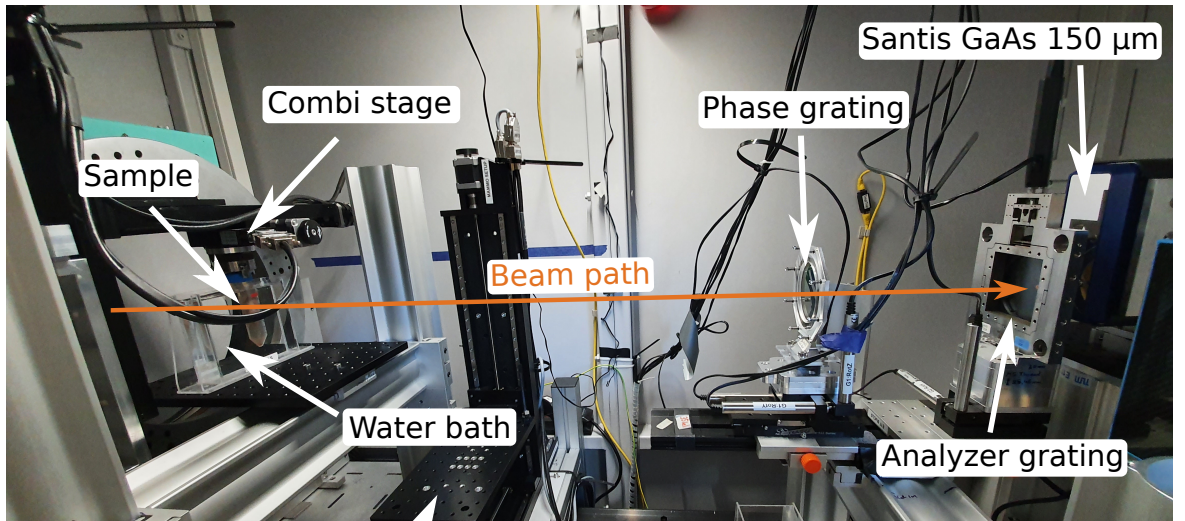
Photograph of the experimental setup of the second hutch at the MuCLS. This setup is used for attenuation-only and grating-based phase-contrast BCT. The sample is mounted hanging into a 3 cm thick water bath in front of the grating interferometer including phase and analyzer grating. The X-ray beam comes from the left side out of the evacuated beam pipe. The detectors are mounted on a movable stage directly behind the analyzer grating on the right side.
